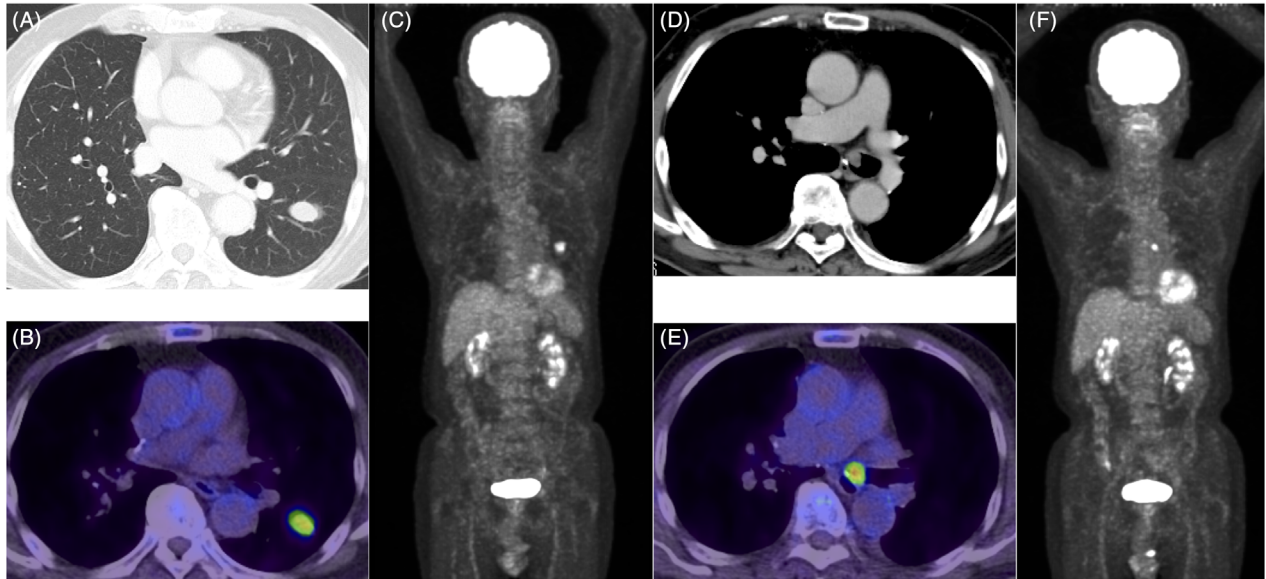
Images before video-assisted thoracoscopic surgery (VATS) combined segmentectomy and at recurrence. (A) Computed tomography (CT) before VATS surgery revealed lung tumour of the left lower lobe. (B, C) Positron emission tomography (PET/CT) showed fluorodeoxyglucose (FDG) uptake of the lung tumour. (D) CT at recurrence revealed an endobronchial tumour in the left main bronchus. (E, F) PET/CT showed FDG uptake of the endobronchial tumour.
